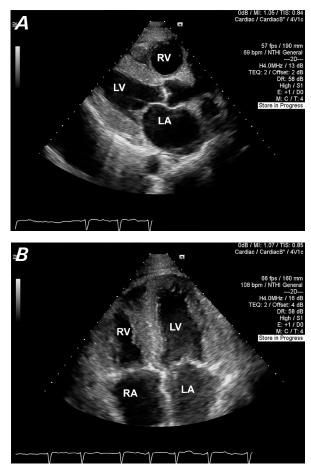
Two-dimensional transthoracic echocardiograms in A) parasternal long-axis and B) apical 4-chamber views show substantial thickening of the left ventricular (LV) and right ventricular (RV) walls, granular sparkling on the myocardial wall, a small LV cavity, biatrial enlargement, and atrial septal thickening, findings consistent with cardiac amyloidosis.
